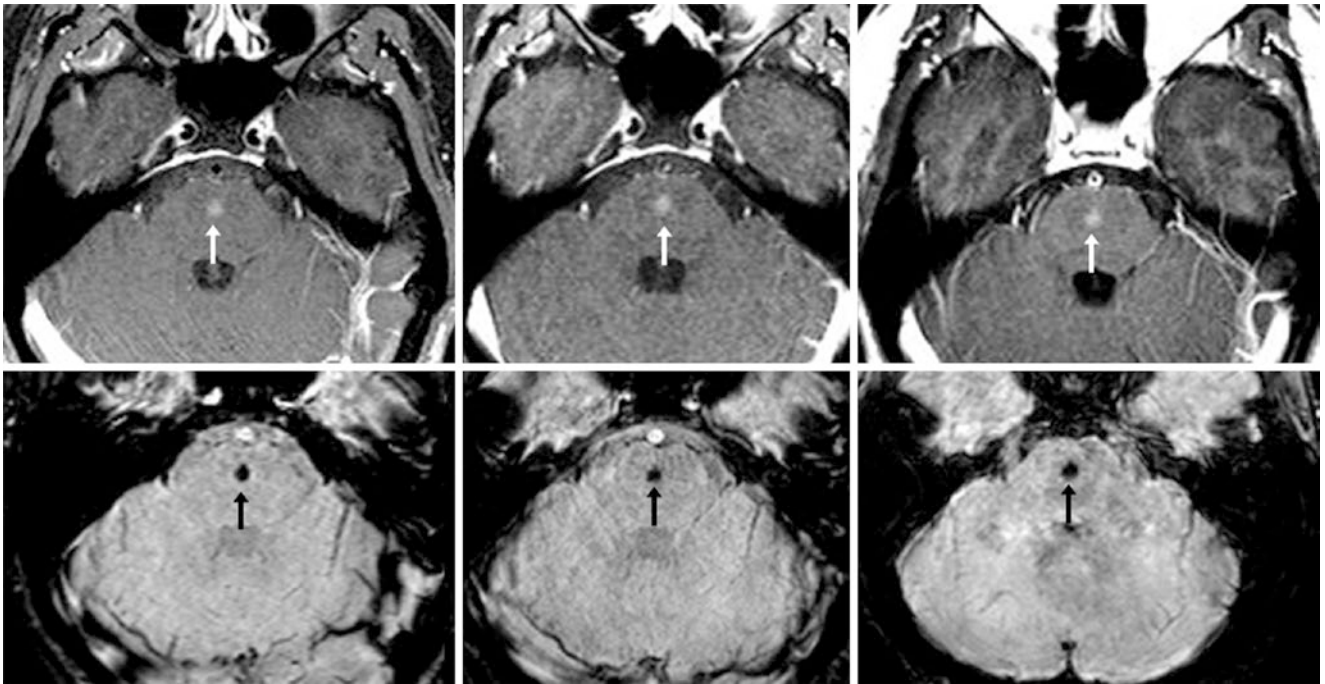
A 26 year old with hearing deficits had a pontine BCT (arrows) on otherwise negative serial 1.5T MRIs that were obtained annually over 3 years; this included postcontrast axial T1WIs (*top row*) and SWIs (*bottom row*). The BCT mildly enhanced and was quite hypointense on SWI but appeared normal on T2WI/FLAIR (*not shown*)
